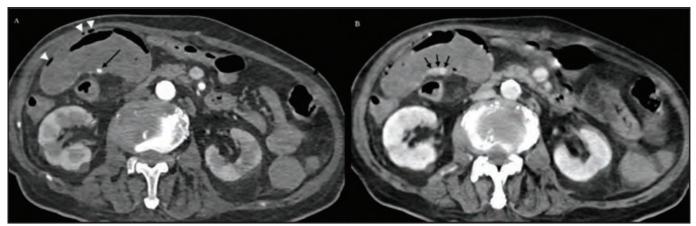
CT mesenteric angiogram of a 76-year-old patient showing (a) focal contrast extravasation within a distended loop of ileum in the arterial phase (arrow) and intra-mural gas (white arrowheads) as well as (b) pooling of contrast by the venous phase (black arrows).
